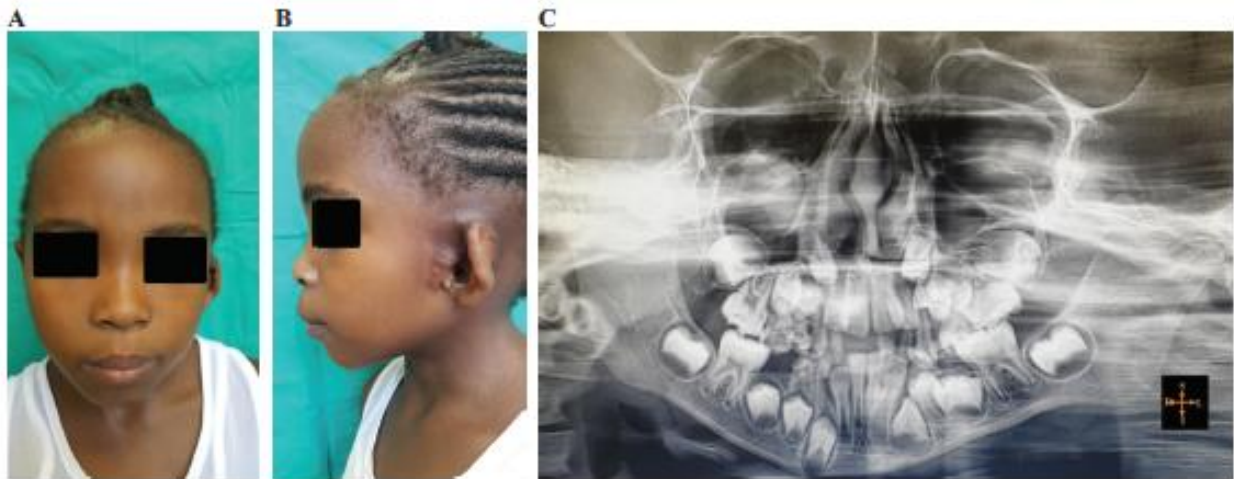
Characteristic features of HFM presentation in a 6-year-old patient based on OMENS classification. (A) A frontal view of a left-sided hemifacial microsomia (HFM) with mild soft tissue defects and a deformed ear. (B) The lateral view shows a mild hypoplasia of the external ear (E1) with most structures intact and mild soft tissue defects (S1). (C) A panoramic radiograph showing a deformed mandible (M2A), crowded teeth. The OMENS classification is O0M2AE1N1S1.
